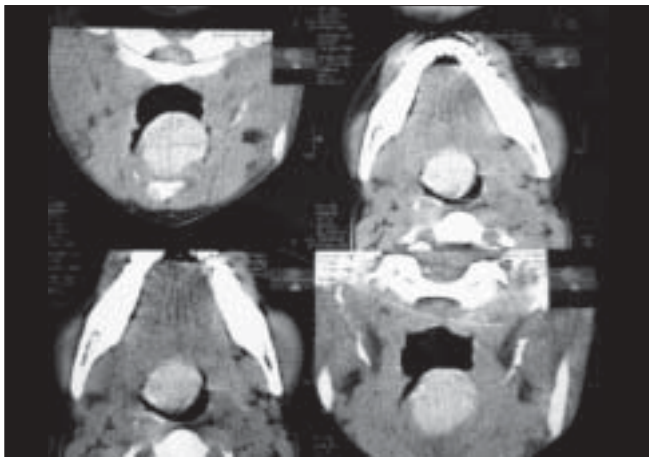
CT scan showing well defined hyperdense soft tissue mass in the right side of vallecula
